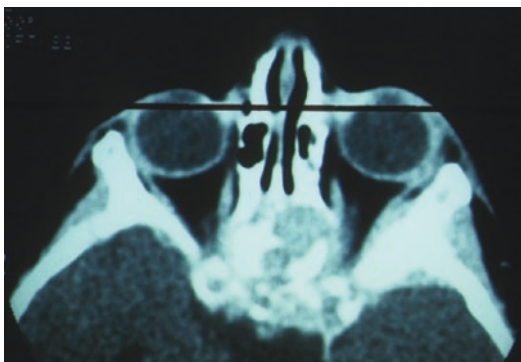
(a) Post-contrast axial CT of the skull: mass lesion of the left ethmoid sinus invading the left orbit and causing moderate proptosis (Ewing's sarcoma); (b)
